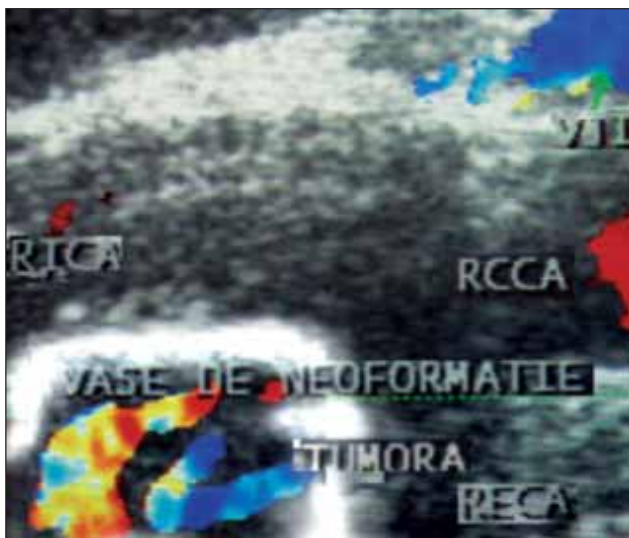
(patient 2). glomus tumor of the right carotid body. Color Doppler sonography: right cervical mass widening the carotid bifurcation
